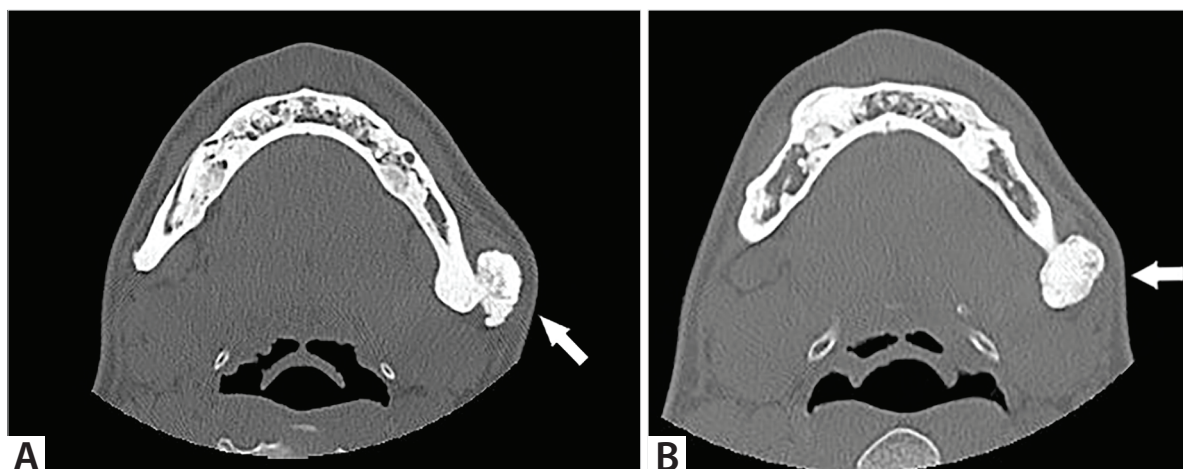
A. Left mandibular osteoma in Maxillofacial CT of case 1, B. Left mandibular osteoma in Maxillofacial CT of case 2.
